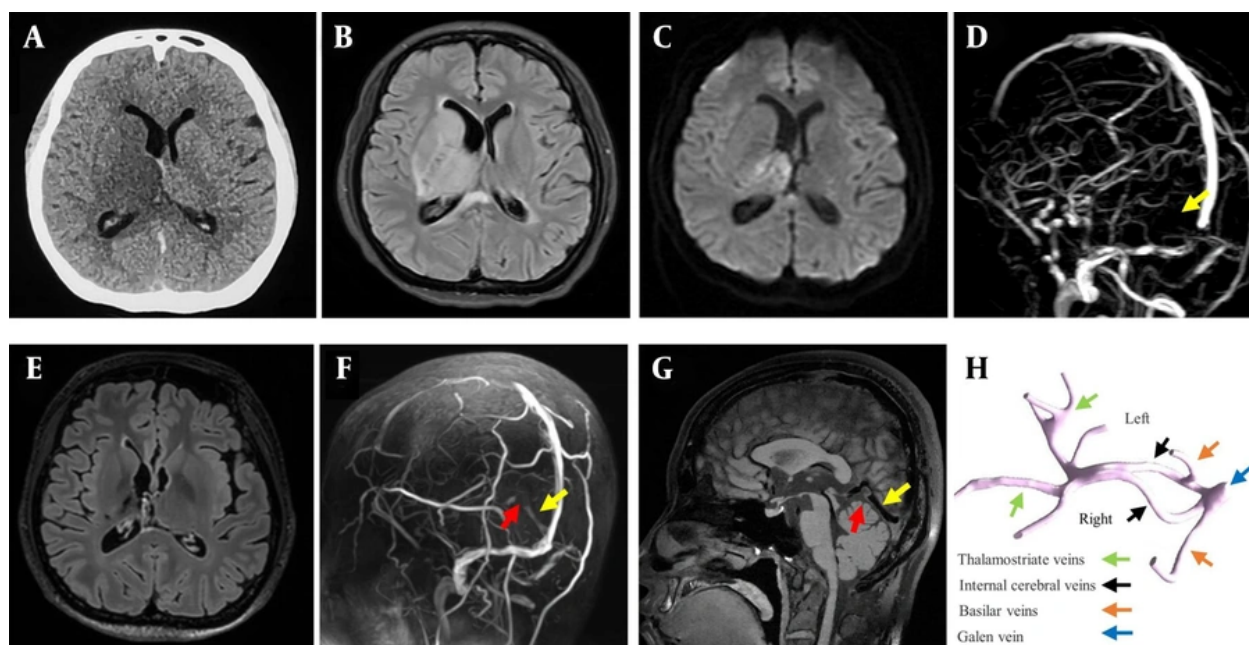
Images of a 31-year-old Asian woman who presented with headache, left limb weakness, and drowsiness. A, Noncontrast computed tomography showed hypodense lesions in the right basal ganglion, thalamus, and splenium of the corpus callosum and hyperdensity of the right internal cerebral vein and straight sinus; B, T2 fluid-attenuated inversion recovery imaging demonstrated a hyperintensity signal involving the right basal ganglion, thalamus, and splenium of the corpus callosum; C, diffusion-weighted imaging showed a heterogeneous hyperintensity signal in the right thalamus; D, magnetic resonance venography revealed absence of the deep cerebral venous system; E, 1-year follow-up T2 fluid-attenuated inversion recovery imaging showed a small patchy area with hemosiderin deposition in the right thalamus; F, 1-year follow-up magnetic resonance venography demonstrated a round filling defect located in the proximal segment of the straight sinus; G, 1-year follow-up high-resolution magnetic resonance vessel wall imaging detected an arachnoid granulation protruding into the straight sinus; H, 3-dimensional reconstruction based on high-resolution images indicated symmetry of venous drainage in the bilateral deep venous system.
